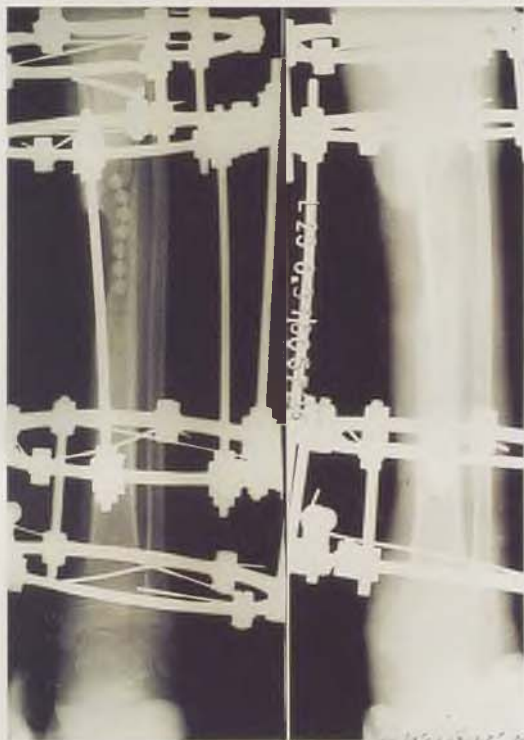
Radiographs at the time of surgery.
